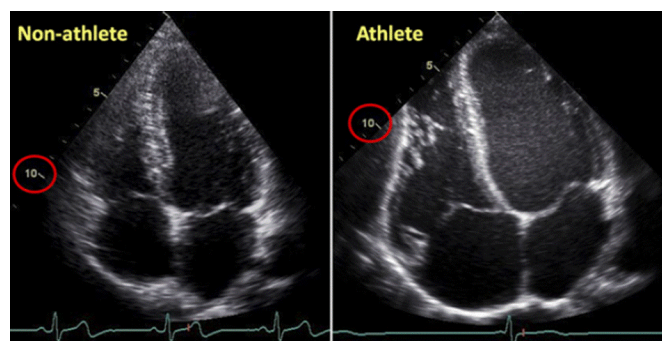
Apical four-chamber two-dimensional echocardiogram of the heart of a 23-year-old non-athlete (left) and a 23-year-old professional cyclist. The volume load of endurance athletics results in dilatation of all four cardiac chambers. The 10 cm echocardiographic field depth is marked in red to highlight the differences in cardiac size. Reproduced with permission.¹⁶
